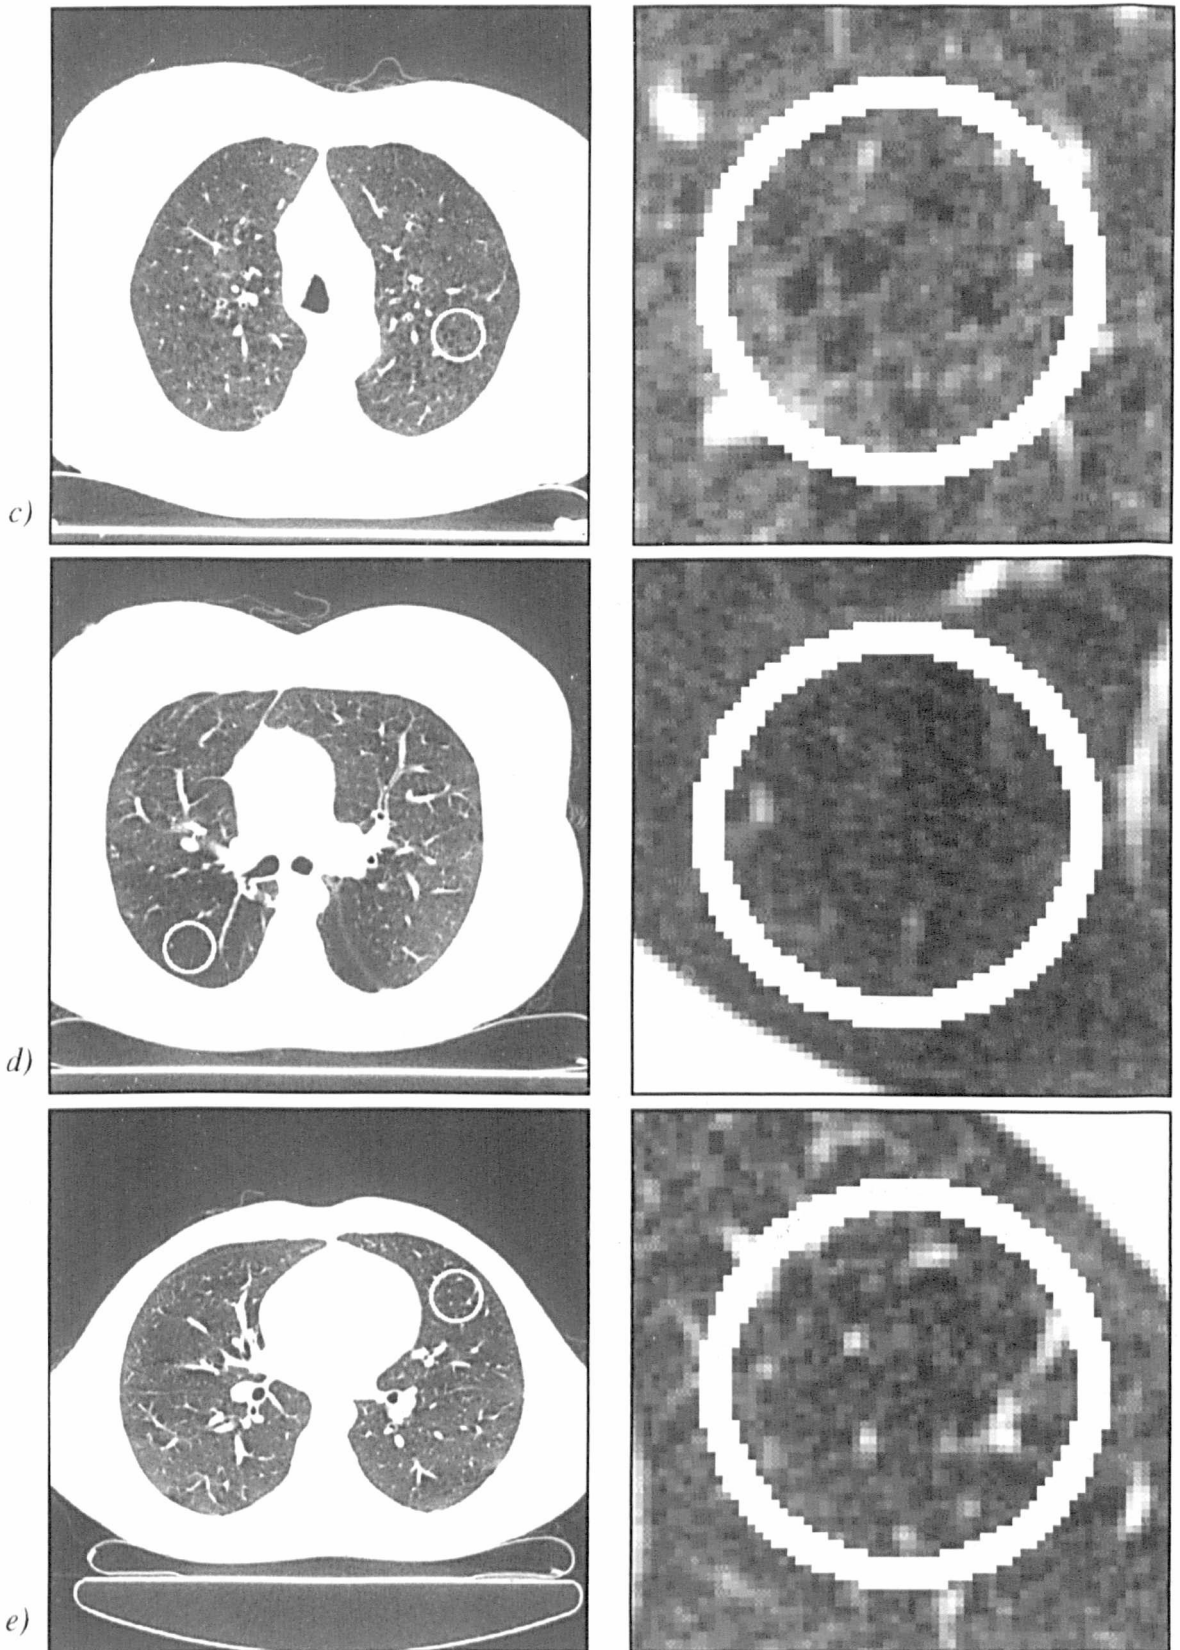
(continued). *c)* Mild centrilobular emphysema: the characteristic appearance of centrilobular emphysema is visible but less obvious than in Figure (1.9b). *d)* Constrictive obliterative bronchiolitis results in hypo-attenuated but homogeneous lung. *e)* Normal subject: the mean CT density of the lung parenchyma is higher than in areas affected by obstructive diseases.
